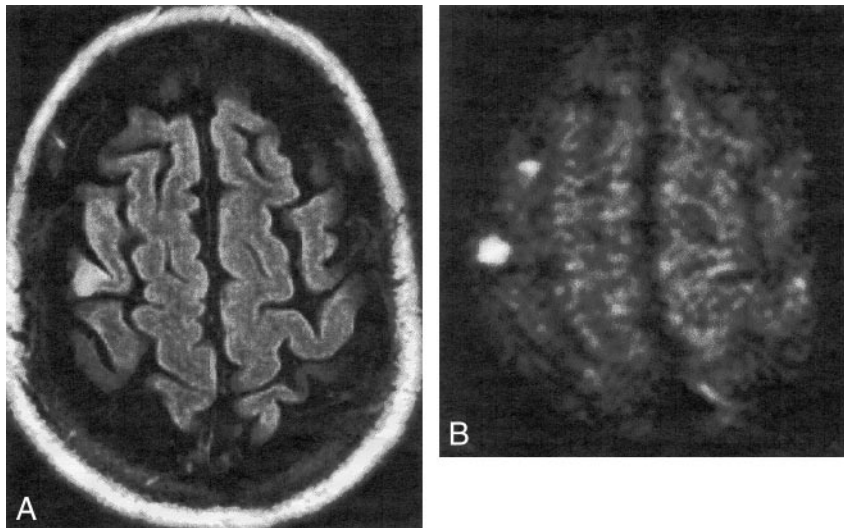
Axial MR images obtained 3 days after symptom onset in a 75-year-old man with left hemiparesis that rapidly resolved within 4 hours of onset.
